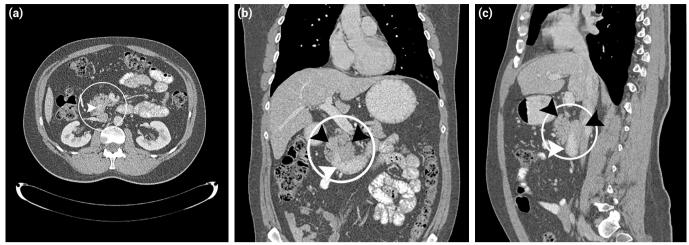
(a) Axial (arrowhead duodenum), (b) coronal (black arrowhead pancreas, white arrowhead duodenum), (c) sagittal CT images of the duodenum surrounded by the annular pancreas (black arrowhead pancreas, white arrowhead duodenum).
